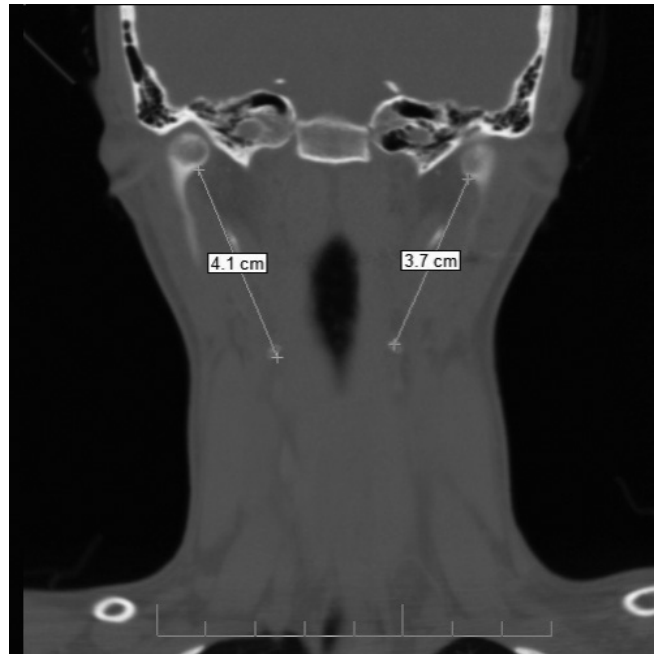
CT scan image showing increased styloid processes: right with 4.1 cm; left with 3.7 cm.
